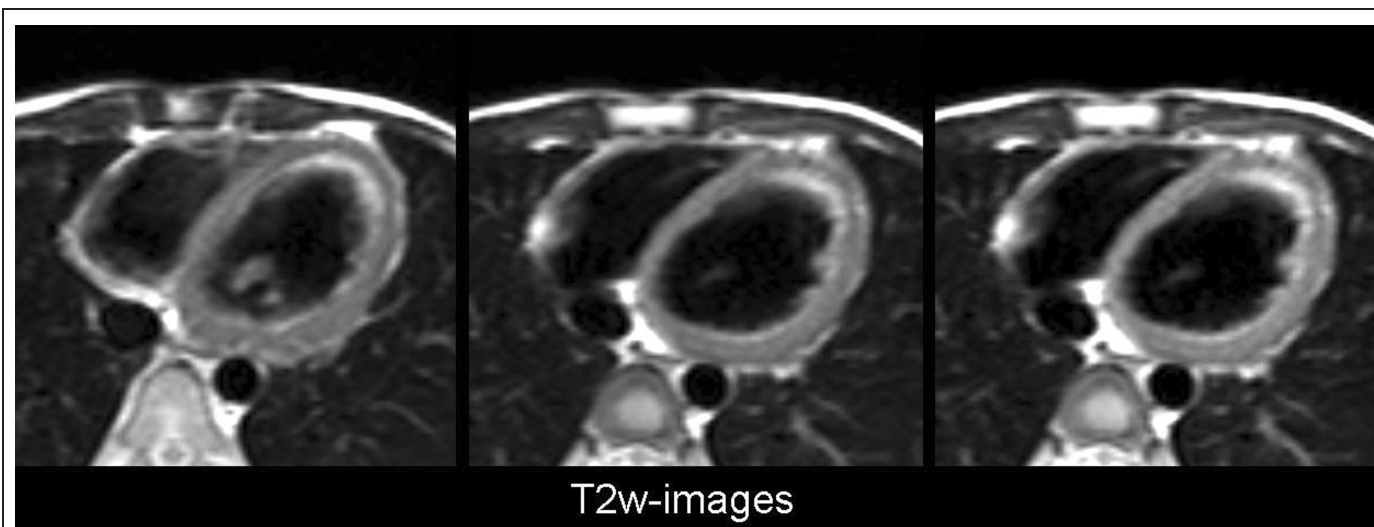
Transaxial T2-weighted images did not show abnormal regional increase of the myocardial signal intensity excluding the presence of edema.
